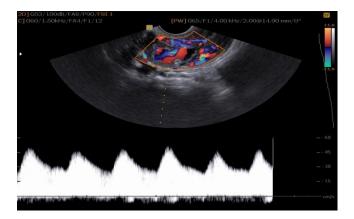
Spectral Doppler Transvaginal US demonstrating peak systolic velocity (PSV) of 51 cm/s and resistive index (RI) of 0.4.
